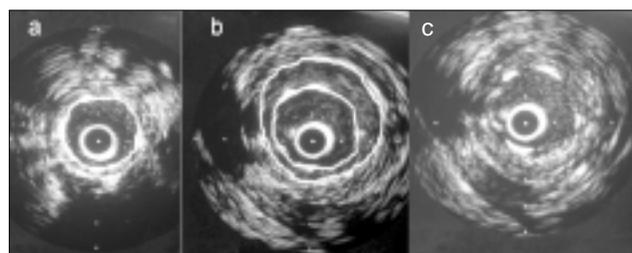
Intravascular ultrasound images showing (a) good stent apposition in the myocardial bridge segment with stent area of 6.1 mm². (b) Image at the site of ectasia within the myocardial bridge showing stent malapposition in diastolic frame. The stent cross-sectional area is 6.8 mm² and EEM cross-sectional area of the ectatic zone is 14.6 mm² (c) Systolic frame at the same site showing complete obliteration of ectasia due to contraction of the myocardial bridge around the stent.
